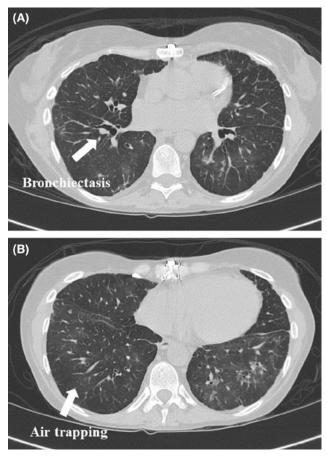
CT scan of a chest showing bronchiectasis (A) and air trapping (B) in a lung transplant recipient, suggestive of CLAD due to BOS. Confirmation of the diagnosis requires a pulmonary function test showing airflow obstruction.
